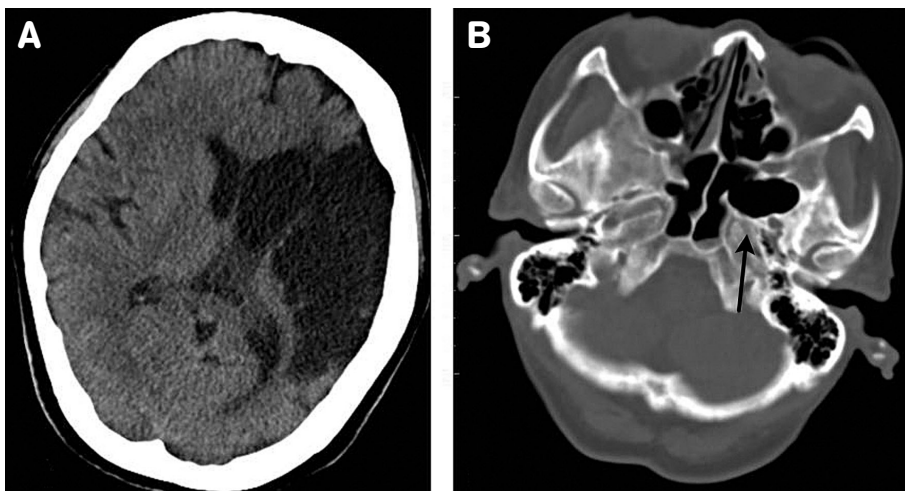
(A) Encephalomalacia is found in the territory of the left middle cerebral artery in transverse brain computed tomography. (B) Bone window from the petrous portion of the temporal region shows absence of the left internal carotid canal (arrow).
